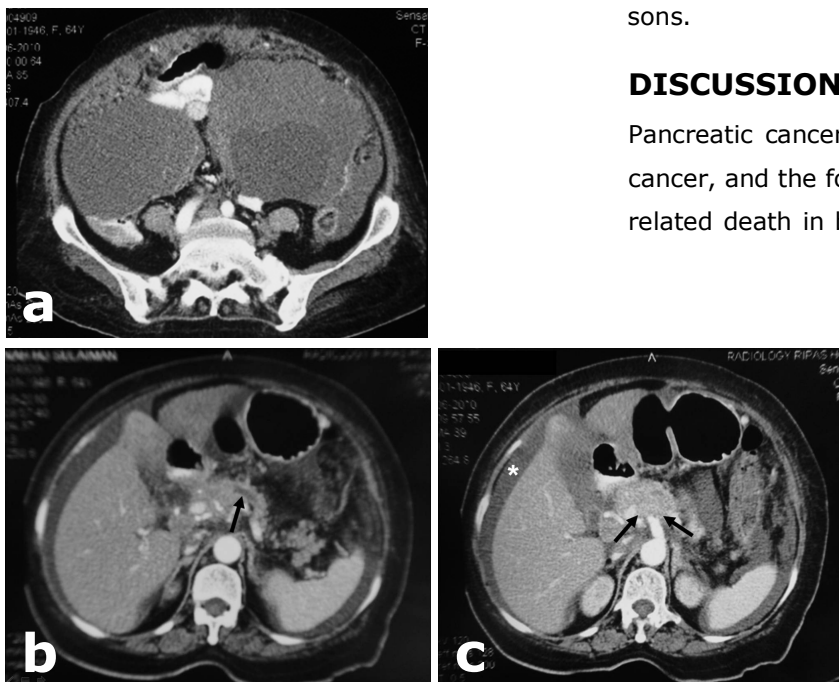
a) Axial computed tomography (CT) scan showing bilateral cystic ovarian mass and ascites, b) CT image showing a dilated distal pancreatic duct (black arrow) with abnormalities of the coeliac axis and, c) A CT image showing a pancreatic mass at the coeliac axis (black arrows) and ascites (white asterisk).
